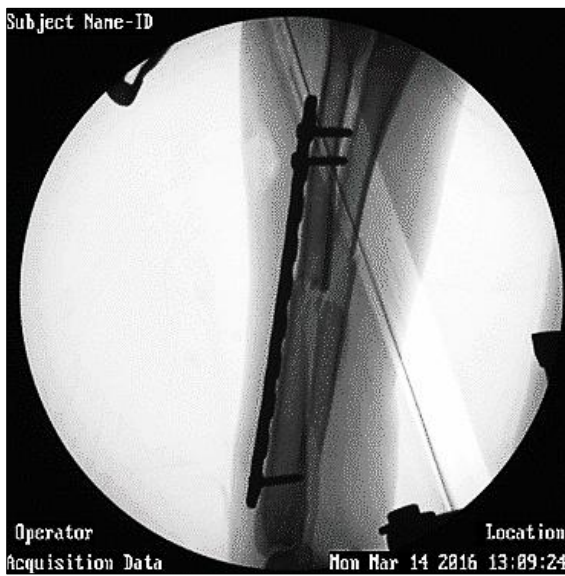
C-arm radiograph showing placement of proximal screws in the plate
